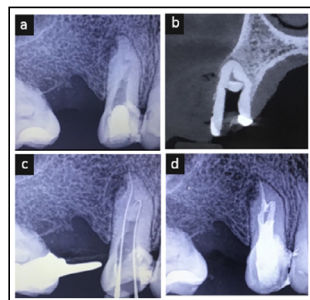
a. Preoperative radiograph. b. Preoperative CBCT. c. Working length determination radiograph. d. Obturation radiograph.
